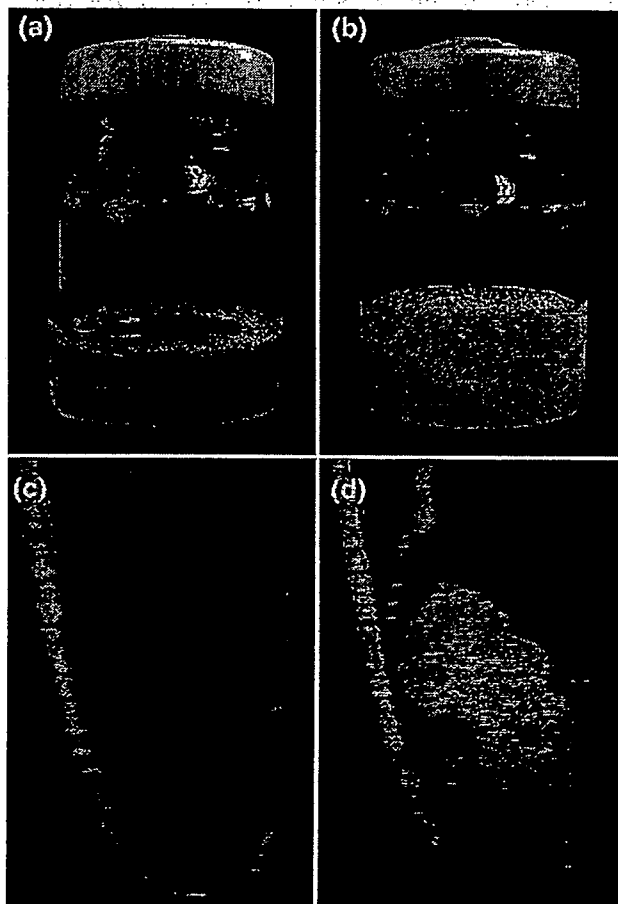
Aspect and ultrasonography of PEG-liposomes and Bubble liposomes. Aspects of PEG-liposomes (a) and Bubble liposomes (b). PEG-liposomes sonicated with perfluoropropane gas became to Bubble liposomes in the vial. Ultrasonographic images of PEG- (c) and Bubble (d) liposomes.
